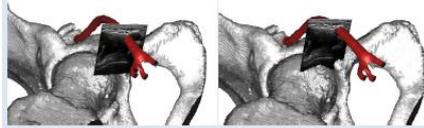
Left: 3D model and ultrasound image visualized after initial registration. Right: After vessel and bone registration.
